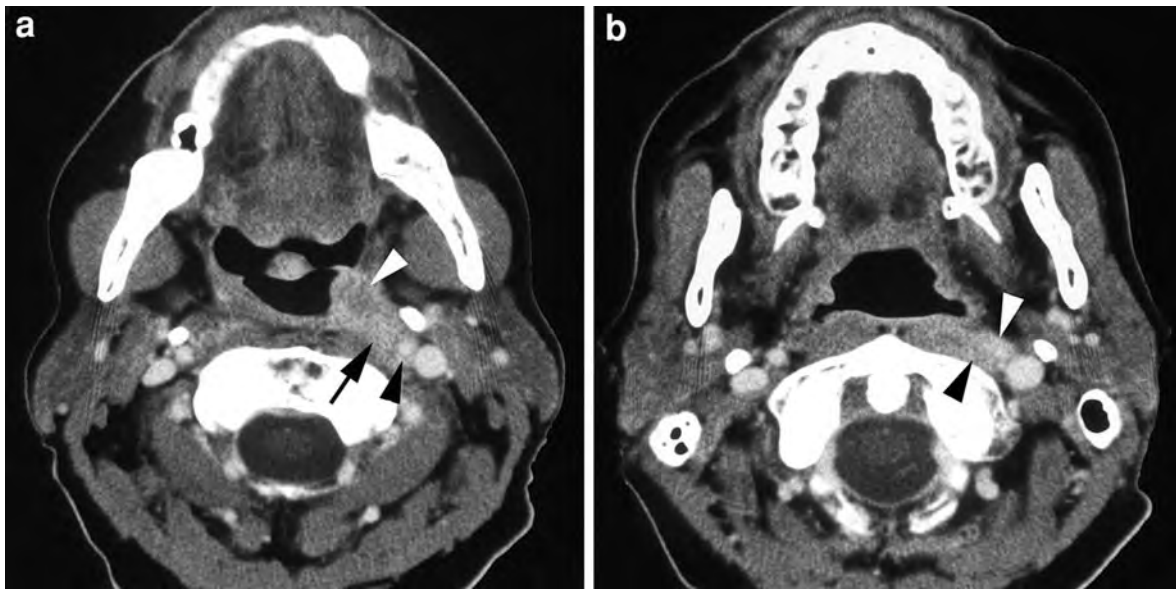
Patient presenting with *left-sided* otalgia. Clinical examinations show *left-sided* tonsillar tumor. Axial contrast-enhanced CT-images. a Level of oropharynx: enhancing mass lesion in *left* oropharyngeal tonsil (*white arrowhead*), extending
